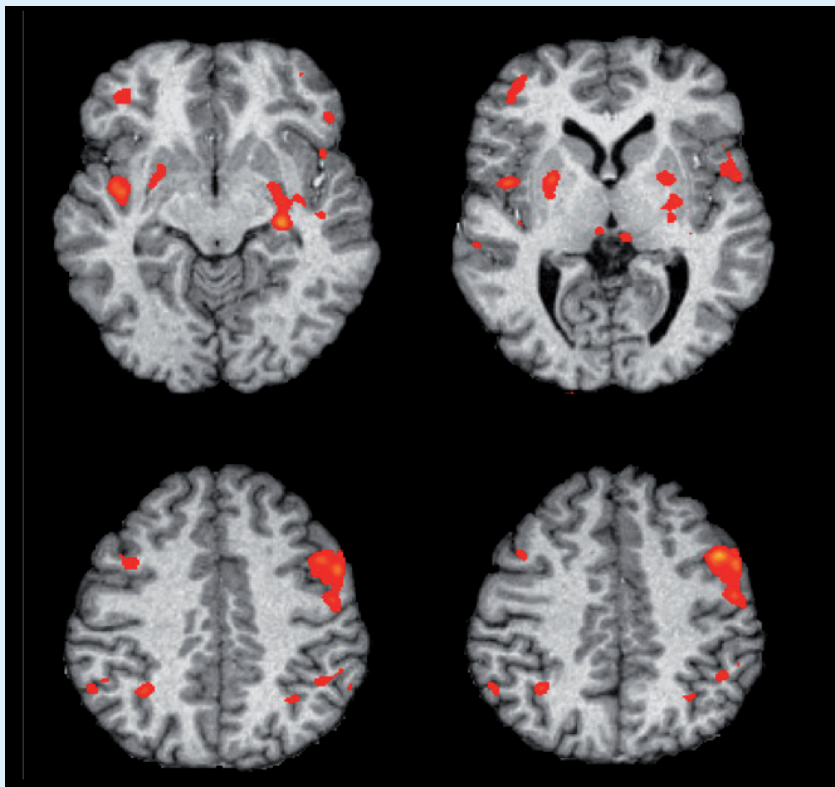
Functional MRI image of local and limbic effects of prefrontal transcranial magnetic stimulation from Li and colleagues [24].
